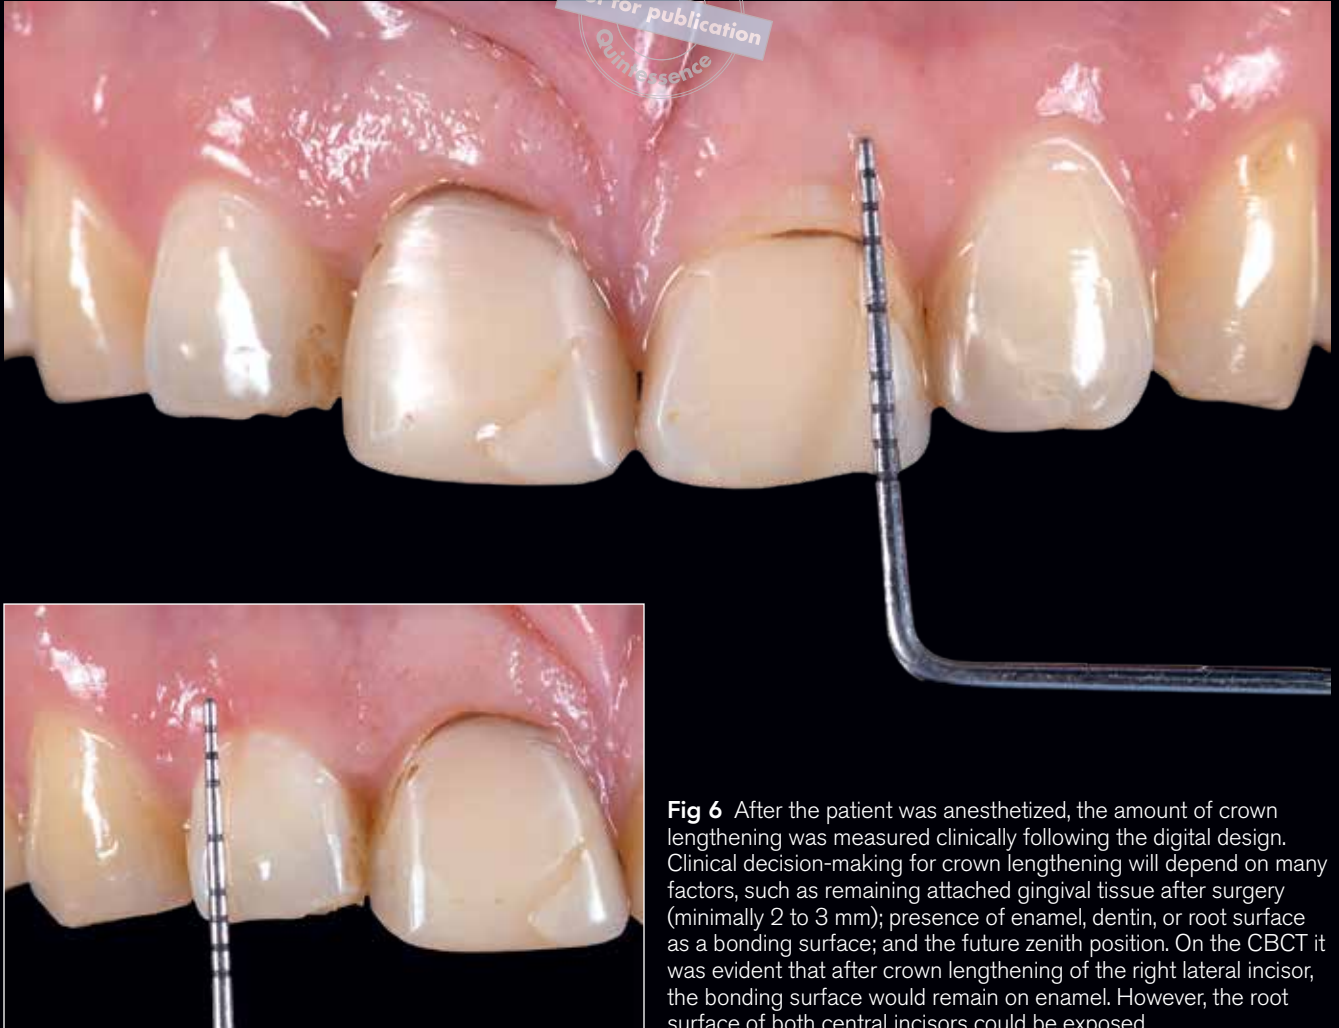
After the patient was anesthetized, the amount of crown lengthening was measured clinically following the digital design. Clinical decision-making for crown lengthening will depend on many factors, such as remaining attached gingival tissue after surgery (minimally 2 to 3 mm); presence of enamel, dentin, or root surface as a bonding surface; and the future zenith position. On the CBCT it was evident that after crown lengthening of the right lateral incisor, the bonding surface would remain on enamel. However, the root surface of both central incisors could be exposed.
